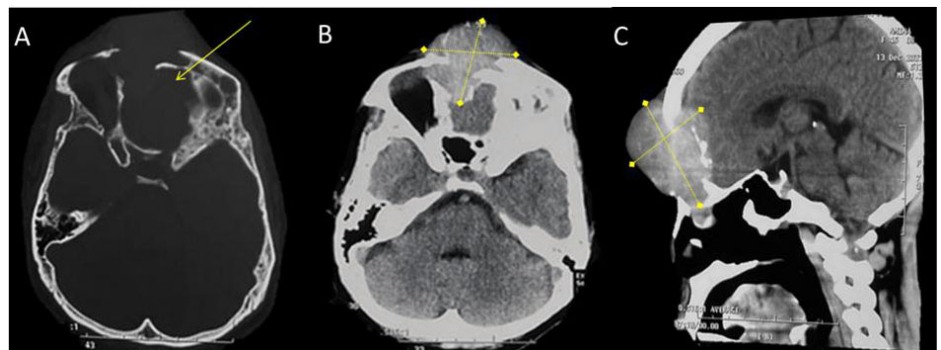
Head computed tomography scan. A. Axial view of the bone window showed sinonasal bone destruction. B. Axial view of brain window showed invasion of the tumor to the sinonasal. C. Sagittal view of brain window showed large tumor coming from intracranial.
